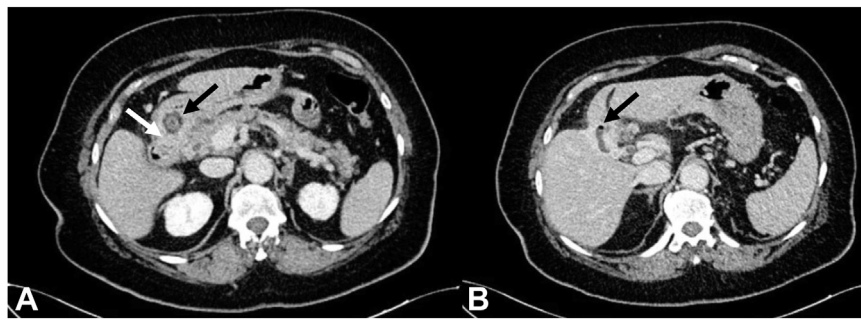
Axial cut of abdomen CT scan showing gallstone (*black arrow, A*) within the duodenum, a cholecystoduodenal fistula (*white arrow, A*), and pneumobilia in the gallbladder lumen (*black arrow, B*).
